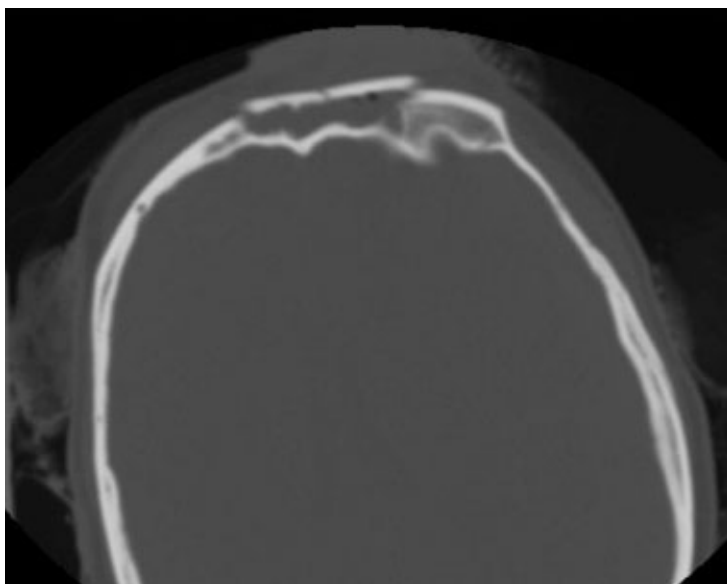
• An axial CT view of a minimally displaced frontal sinus fracture. The posterior table appears intact, and the frontal sinus is completely opacified.
